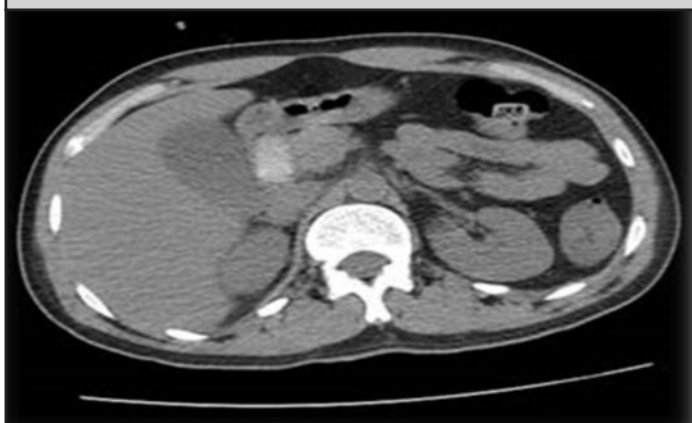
Unenhanced CT scan axial section taken at the level of small bowel. This shows a capsule in 2nd part of duodenum which appears less dense (average attenuation 110 Hounsfield units) representing disintegration of capsule
